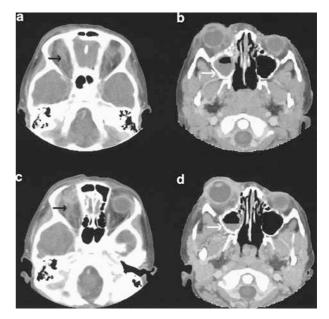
Contrast-enhanced CT scan of the orbits and paranasal sinuses on presentation (a, b) and 4 days later (c, d). Black arrows point to the dilated right superior ophthalmic vein. White arrows point to the opacified right maxillary sinus.
